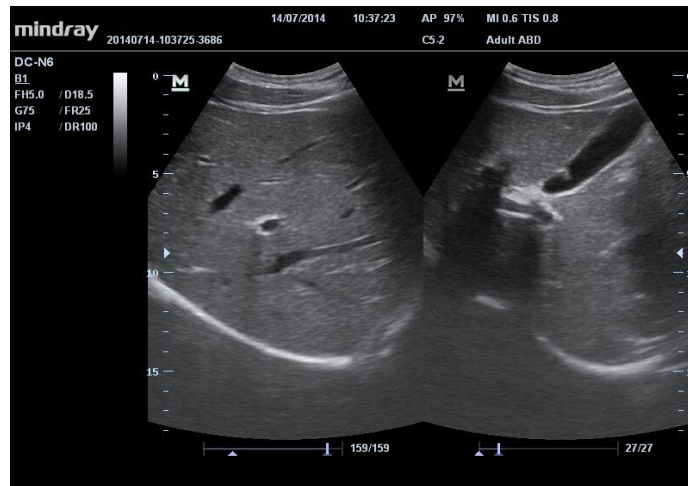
Ultrasound image of 40 years female showing normal liver and gallbladder.
